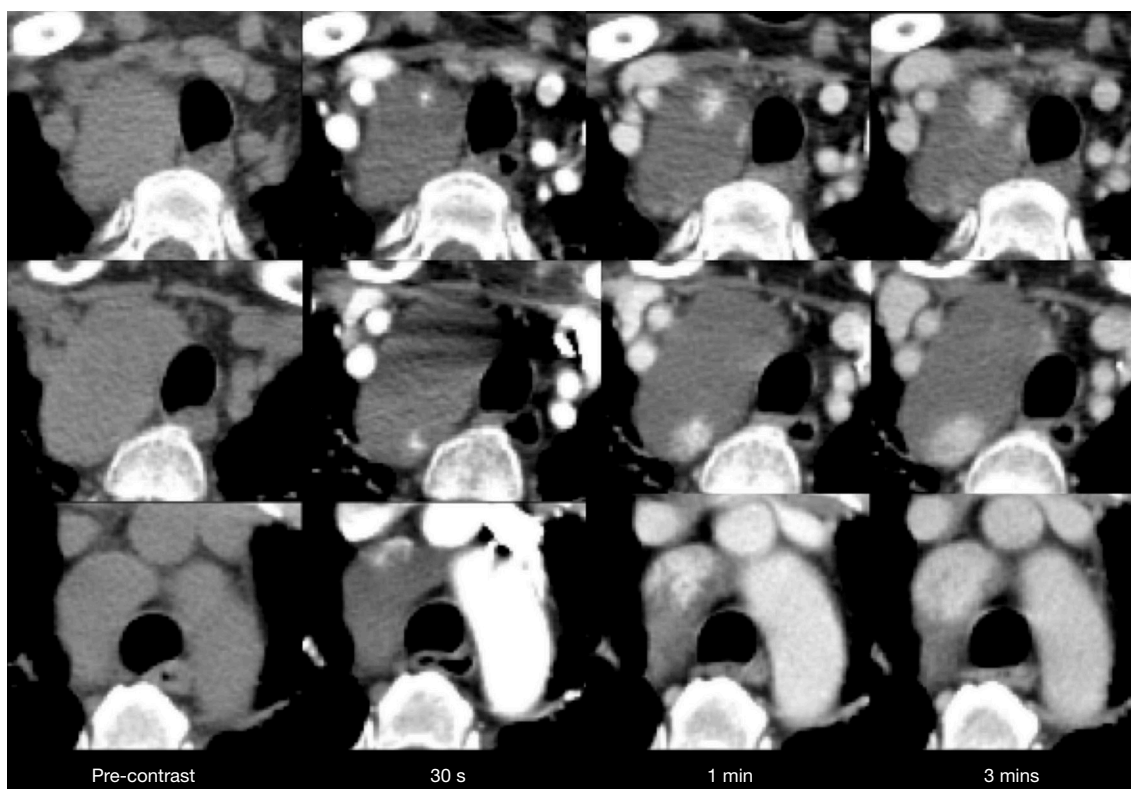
Dynamic computed tomography images were composed of pre-enhanced, 30 seconds, 1min and 3mins phases following intravenous contrast medium administration at the different level of the mediastinal mass, which showed peripheral nodular enhancement on arterial phase images and progressively centripetal fill-in on delayed phase images.
